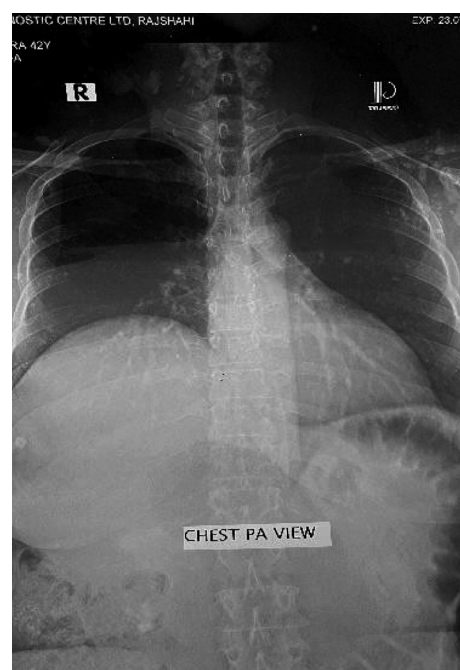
Chest X-ray shows no abnormality. Fig. 4: Post-operative materials containing Multiple Daughter Cysts
